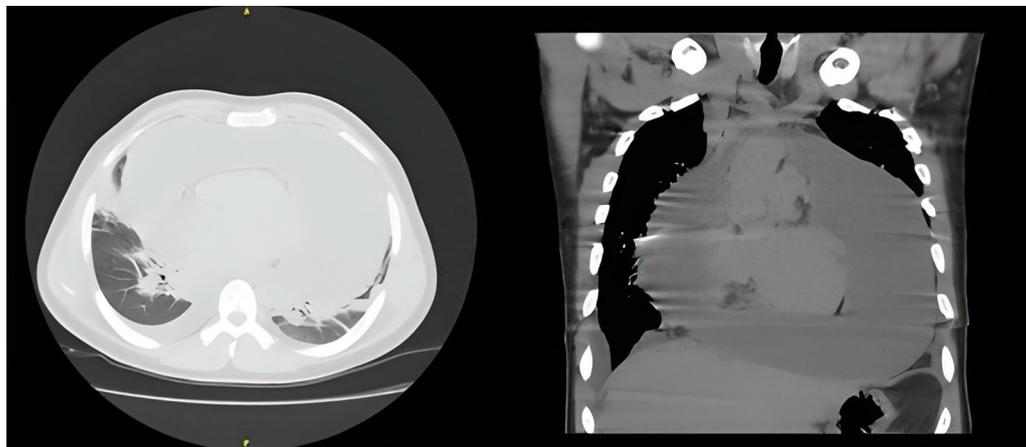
Chest computed tomography showing a massive pericardial effusion
